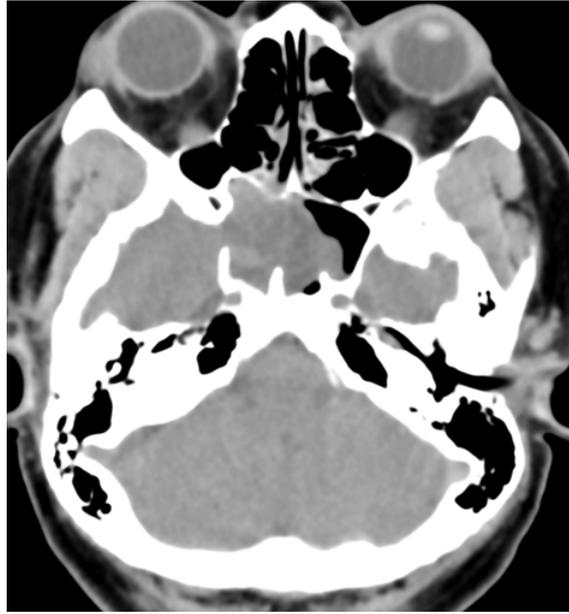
Axial non-contrast CT demonstrates the herniated brain parenchyma in the right part of the sphenoid
